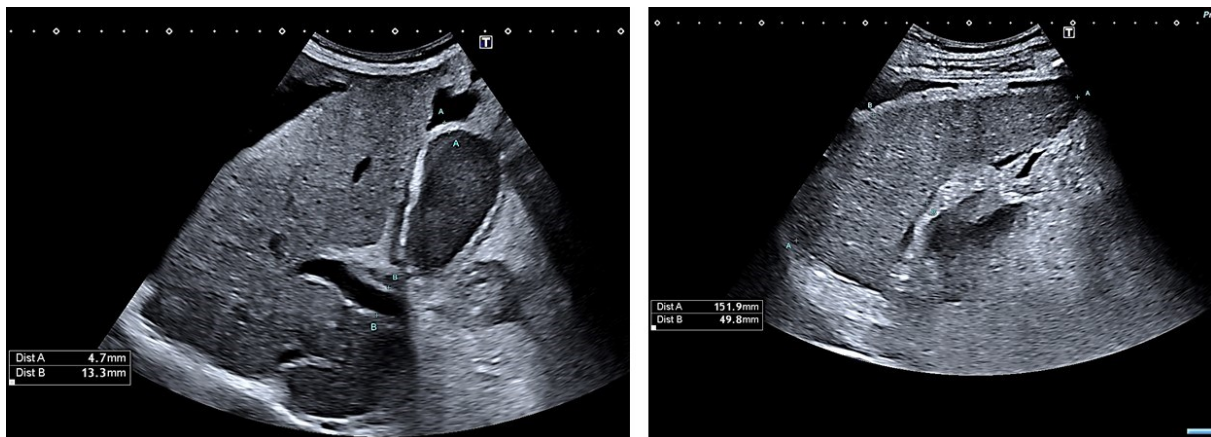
a.1. Morphological signs of portal hypertension by grey-scale (B-mode) ultrasound. Cirrhotic liver surrounded by ascites, dilated portal vein ( $>13$  mm), gallbladder wall edema ( $>3$  mm) (left panel). Splenomegaly ( $>13$  cm) (right panel).
